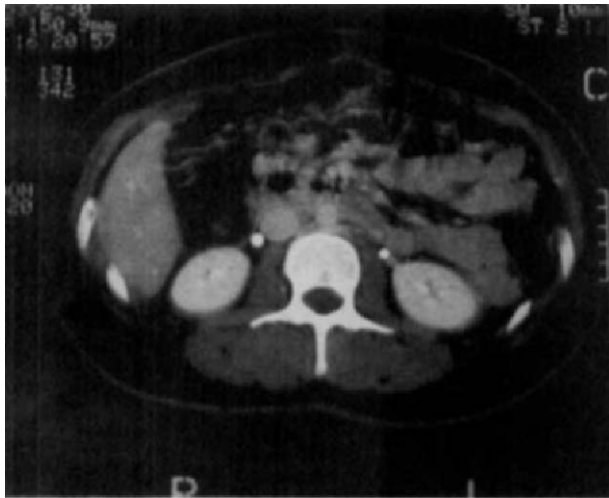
Follow-up abdominal CT scan 2 months after surgery. IVC is free of thrombus.
